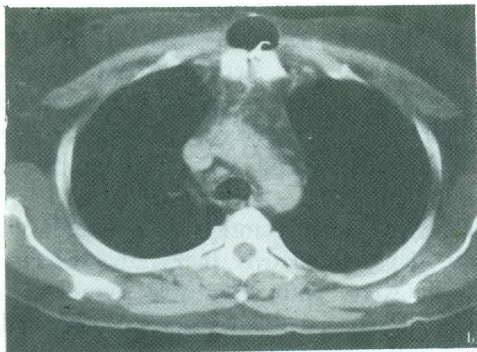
CT scan of the same patient in fig.1 demonstrating loose wire and sternal dehiscence .
